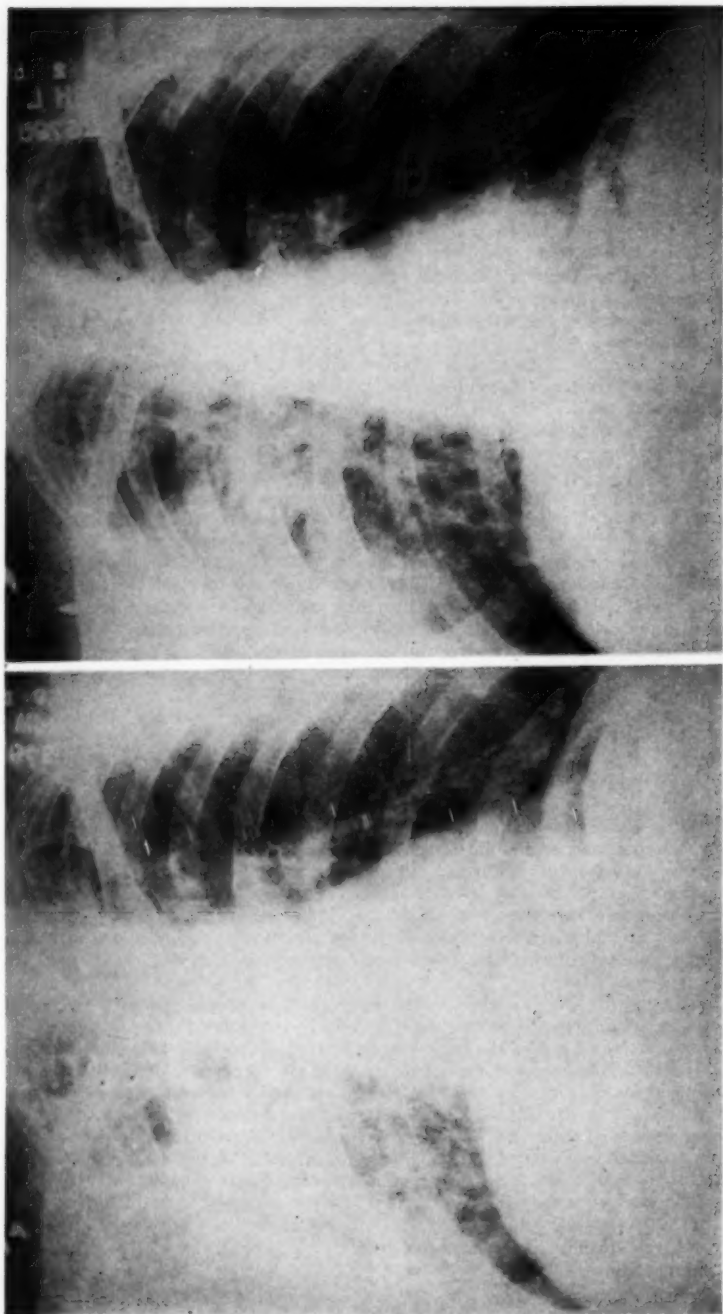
(left). Case 1. Chest roentgenogram on second admission prior to cortisone. Extensive patchy infiltration both lungs.
